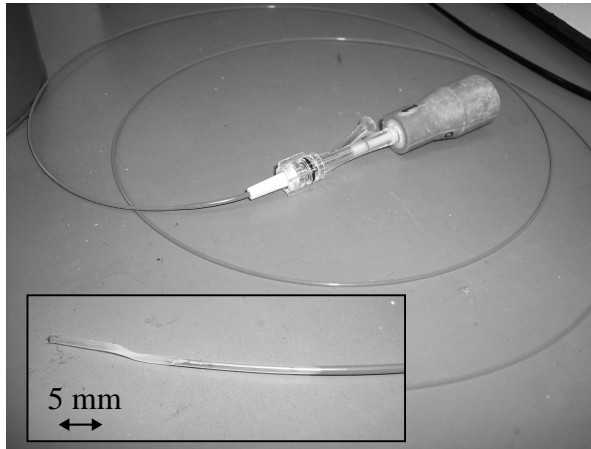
Conventional intravascular ultrasound catheter (Princede 4.3F CCS, Du-MED) and close up of the catheter tip.
